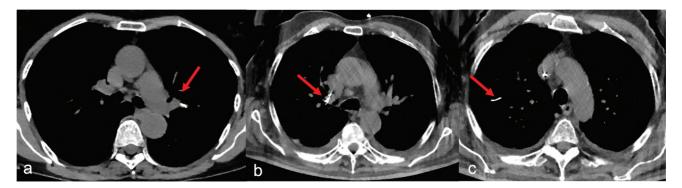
Axial computed tomography depicting pulmonary cement embolism (a) in the main left upper lobe pulmonary artery, (b) in the main right upper lobe pulmonary artery, and (c) in the right segmental artery (*red arrow*).
